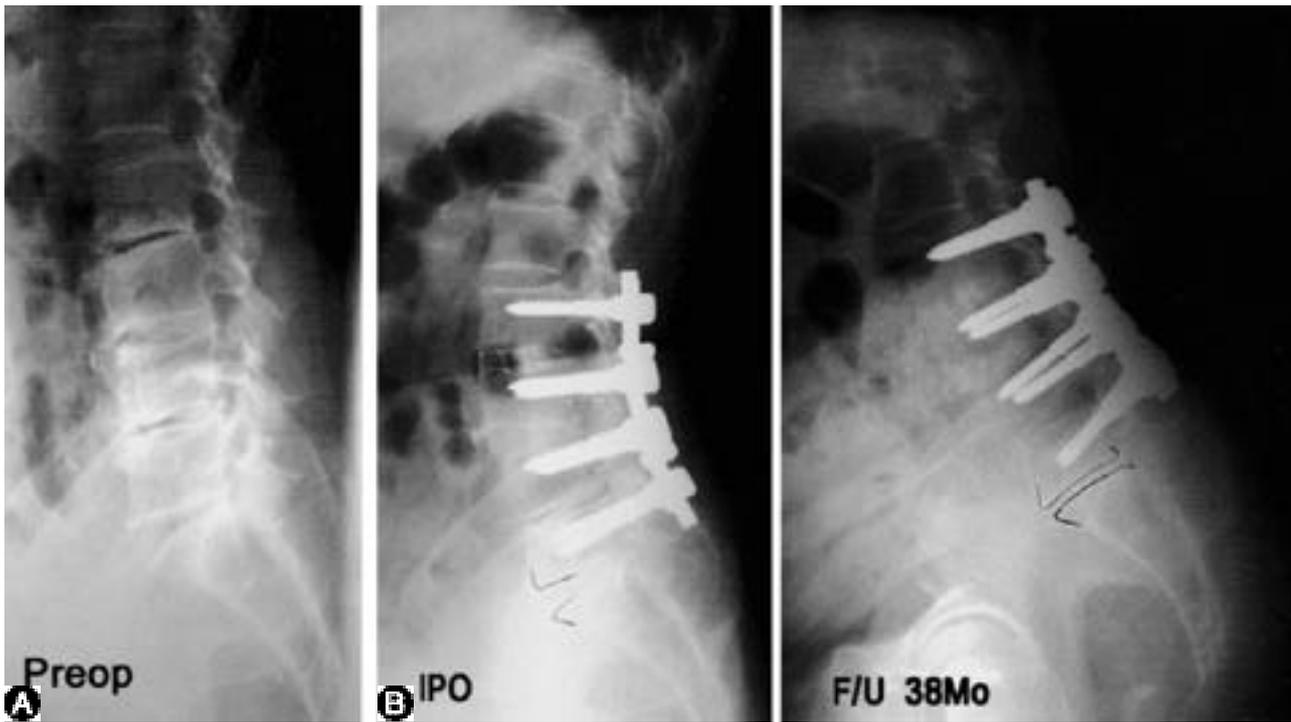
Preoperative lateral side radiography of 67-year-old man shows degenerative lumbar kyphosis, and HNP L2-3-4-5.
